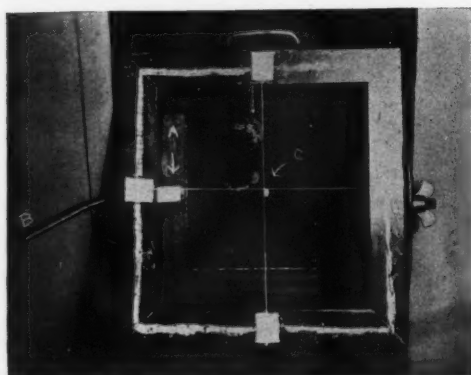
(a) Fixed ionization chamber; (b) ionto-quantimeter cable; (c) X-ray tube target.
